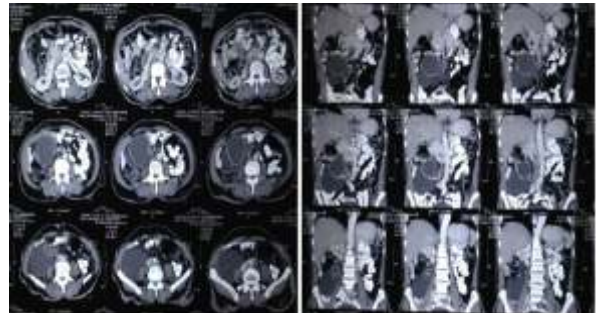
Fig 1. Axial and coronal sections of the CT scan showing a multiloculated cyst measuring 13x7 cms predominantly in right lower abdomen with enhancing walls and septations suggestive of a mesenteric cyst.
